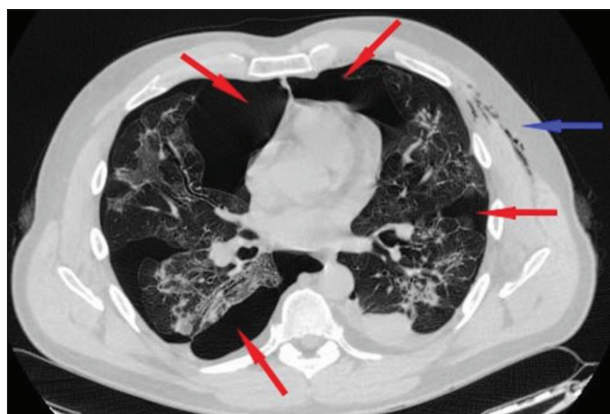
Chest computed tomography scan on admission; red arrows show bilateral pneumothorax; blue arrow shows subcutaneous emphysema
